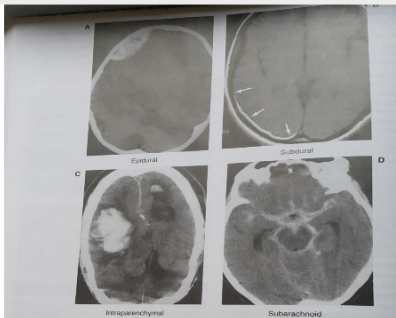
Examples of intracranial hemorrhages on CT scans. (A) Epidural hemorrhage. (B) Subdural hemorrhage. (C) Intracerebral hemorrhage. (D) Subarachnoid hemorrhage. Arrows point to the subdural hemorrhage.
